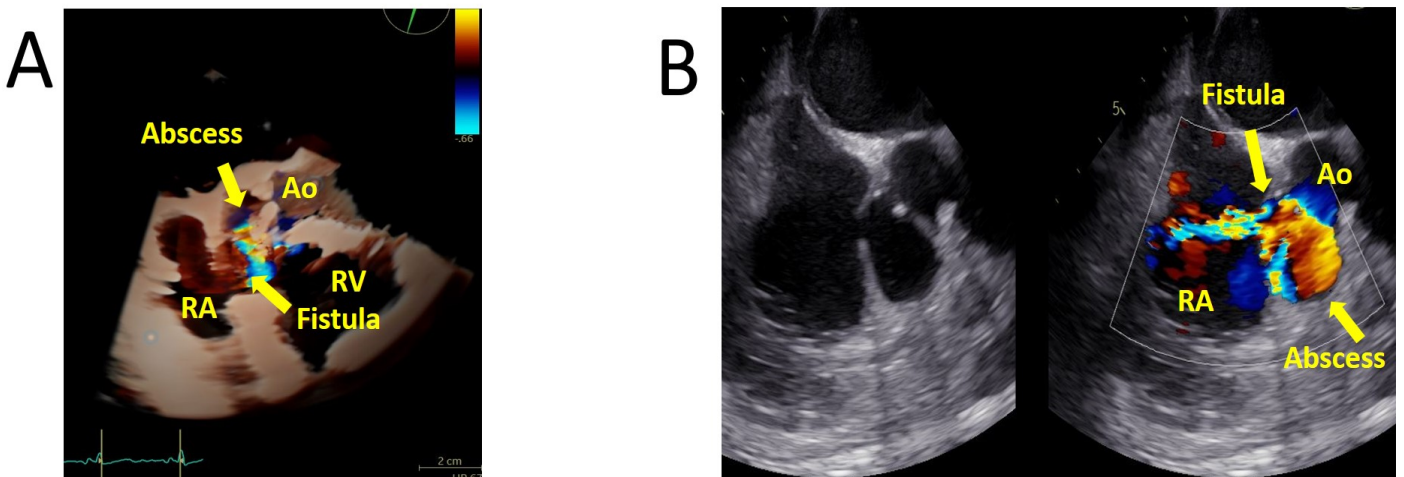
A) Long axis in TEE: turbulent flow through a fistula from the aortic abscess to the right atrium; B) 4CH: focus on the atria which shows at color Doppler a turbulent flow from the aortic abscess to the right atrium. Ao, aorta; LV, left ventricle; RV, right ventricle; RA, right atrium.
